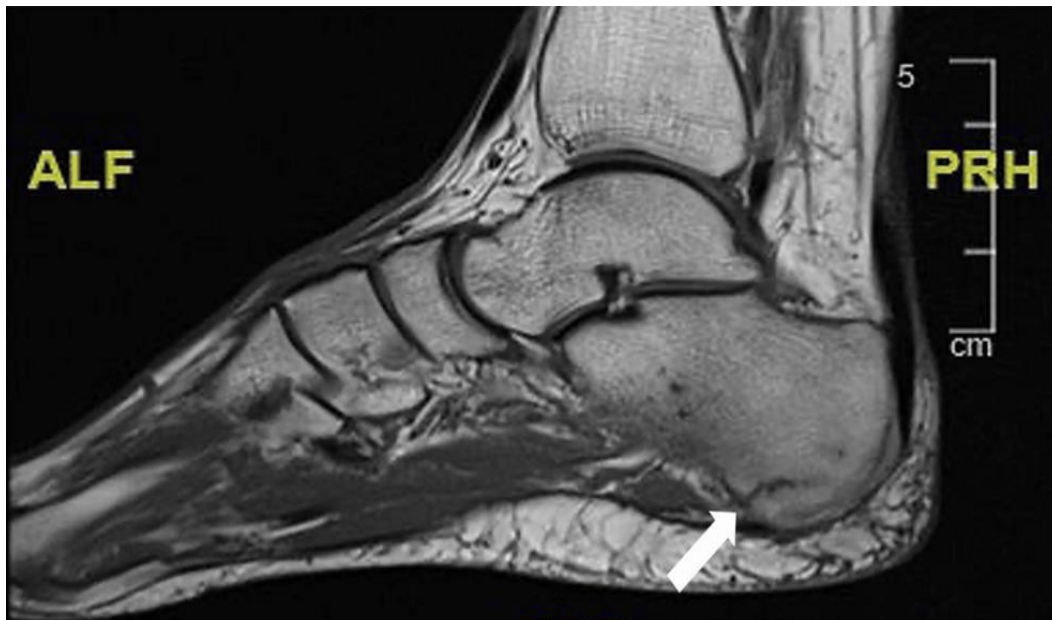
MRI showing tendon thickening.
